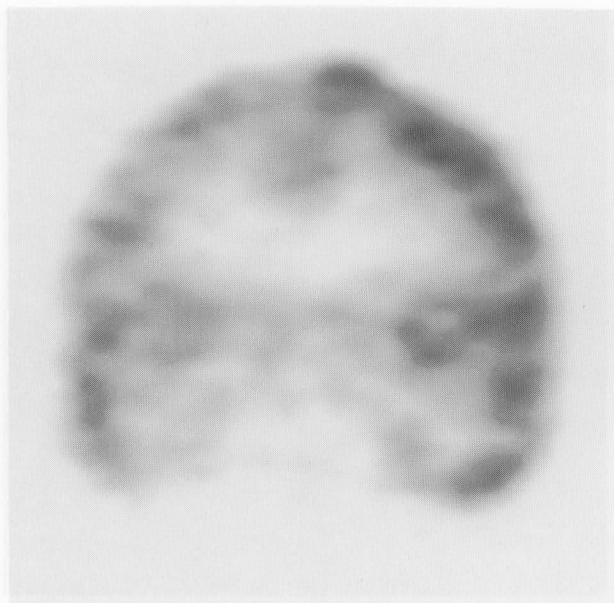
The coronal image of FDG PET scan following surgery and radiotherapy showing no apparent residual FDG uptake in the tumor.
